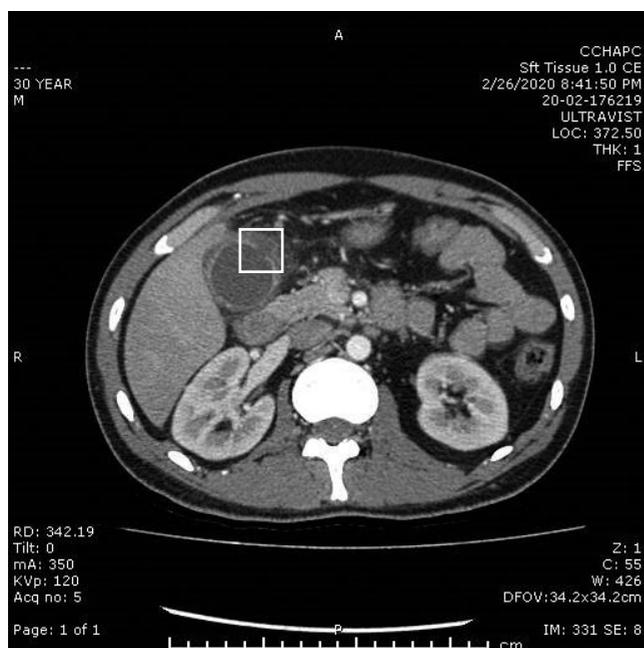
CT Image 2 of gallbladder perforation (marked)
